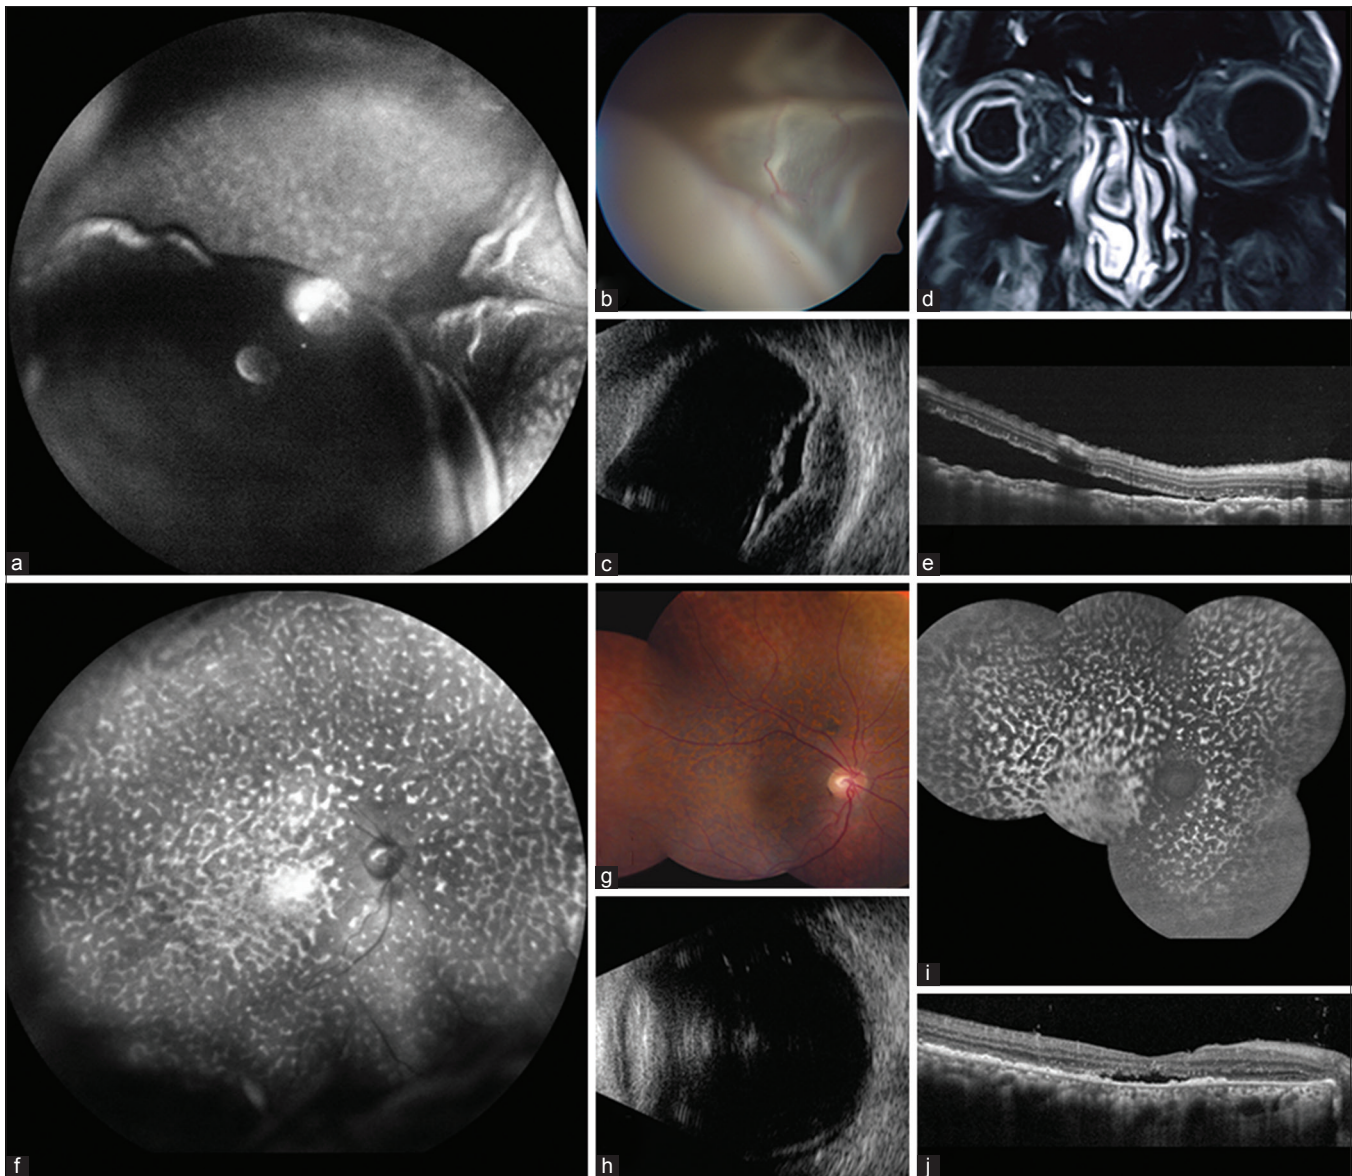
Uveal effusion by (a) wide-angle and (b) macular image, with (c) retinal and choroidal elevation on ultrasonography. (d) Magnetic resonance imaging (T1) with gadolinium, showed uveal detachment. (e) Optical coherence tomography confirmed submacular fluid. Following pericocular and intravitreal corticosteroids, there was (f) fluid resolution with retinal pigment epithelial mottling, (g) flat retina, (h) confirmed on ultrasonography, and (i) lipofuscin deposition on autofluorescence. (j) Optical coherence tomography showed trace subfoveal fluid with outer retinal atrophy. Final visual acuity was 20/150
